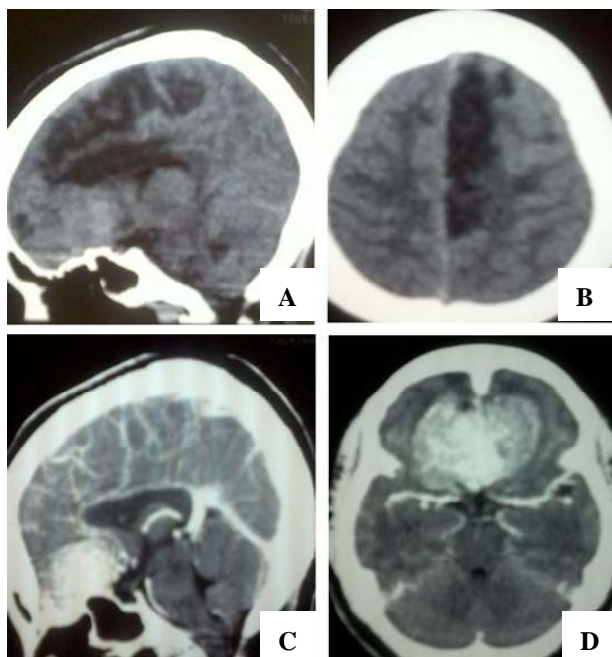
CT scan without injection (A), (B) and injection (C), (D) showing a frontal meningioma infiltrating anterior cerebral artery with infarction in the left callosal marginal artery territory.
